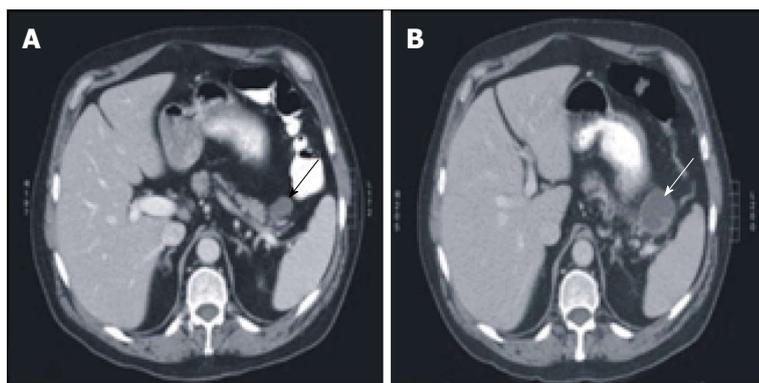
Lymphoepithelial cyst of the pancreas may increase in size during observation. Contrast enhanced computed tomography images demonstrate that the cyst increased from 2.6 cm (A, black arrow) to 4.2 cm (B, white arrow) over a two-month period.
